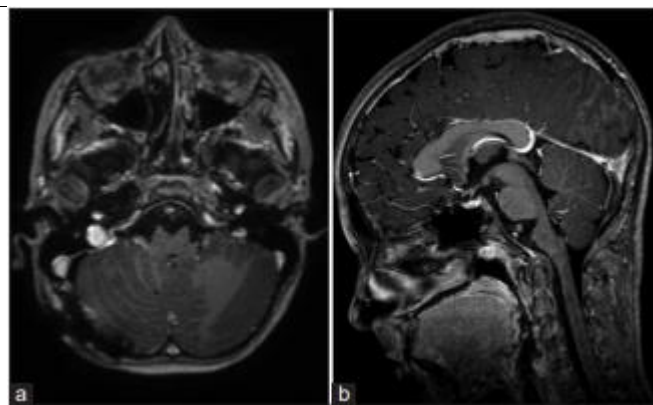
Postoperative T1 sequence brain magnetic resonance imaging with gadolinium (a) axial view and (b) sagittal view demonstrating resolution of the mass impact on the brainstem and no visible residual cyst.
